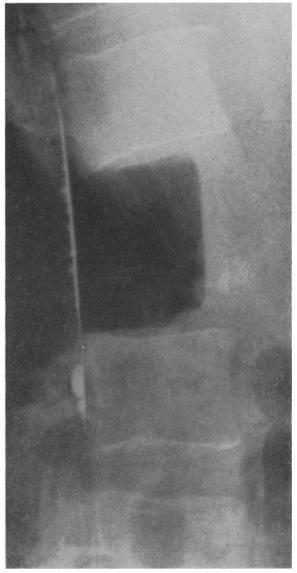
Case 1. Radiograph taken during the procedure when the excision is almost completed (lateral view). The remains of radio-opaque substance in the dural sac can be seen as a straight line.
